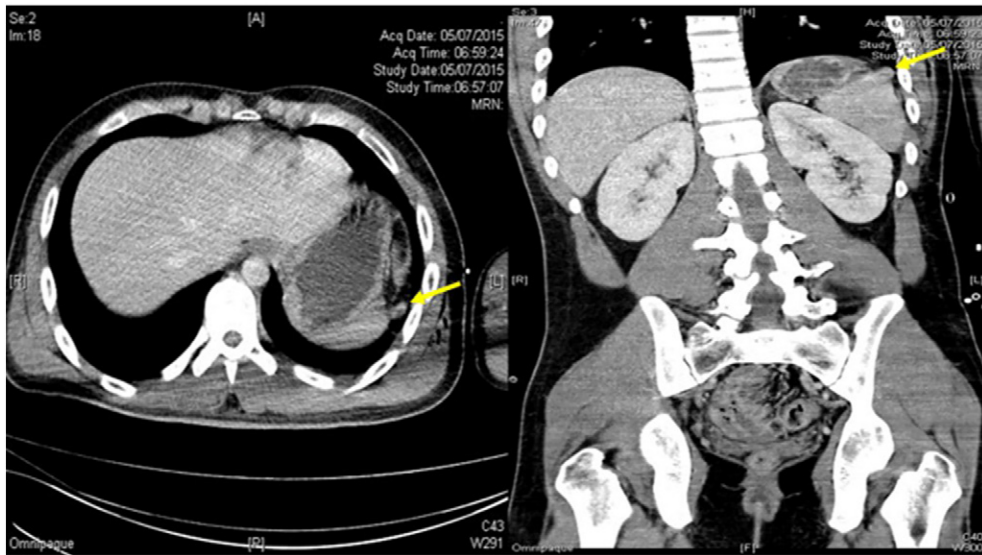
CT scan showing a focal defect over lateral aspect of left diaphragm with protrusion of a small amount of peritoneal fat and nubbing of spleen through the defect (arrow).
